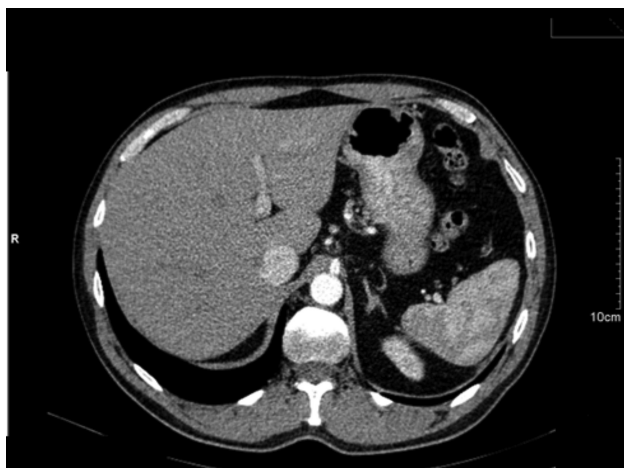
Computed tomography of the abdomen on an adult male patient after a right adrenal pheochromocytoma was removed
